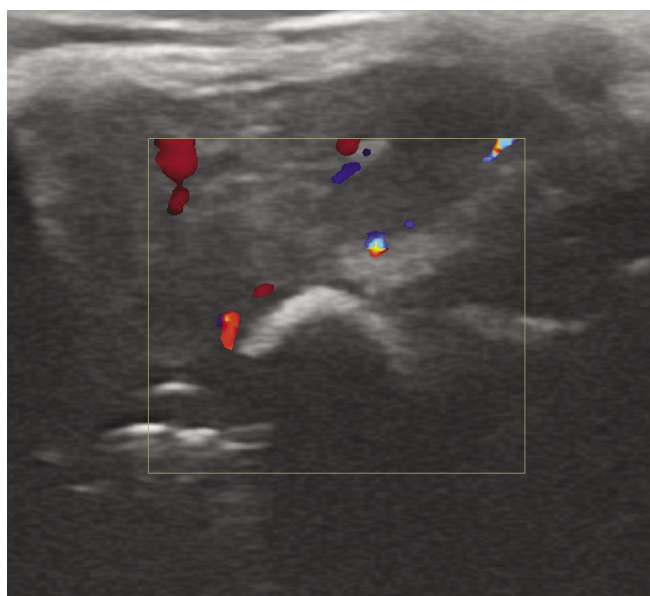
Color Doppler of the lesion, with no vasculature observed
